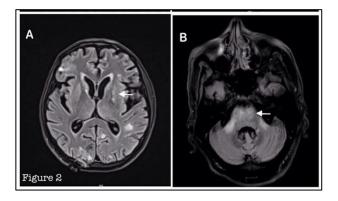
Axial T2 FLAIR images (A and B) show significant reduction in number and size of lesions with significantly reduced perilesional vasogenic edema (shown by arrows) with better visualisation of ventricular system.
